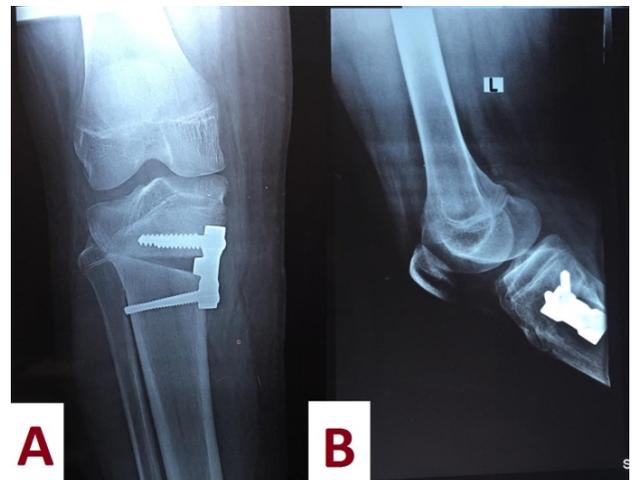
A case study of Male patient 25 years with genu varum: A, B) Intraoperative after plate fixation. C,D) Preoperative plain x-ray AP & lateral view
